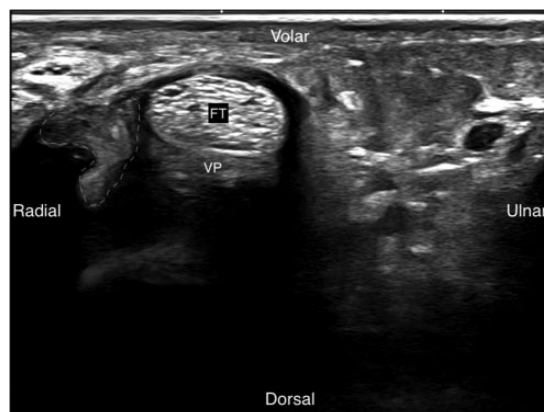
Short-axis sonogram of the MCPJ of the index finger (volar). There is increased hypoechogenicity and a soft tissue flap (dotted white outline) on the radial side of the joint, suggesting a radial-sided injury. The flexor tendon and volar plate are intact. FT: flexor tendons; VP: volar plate.
